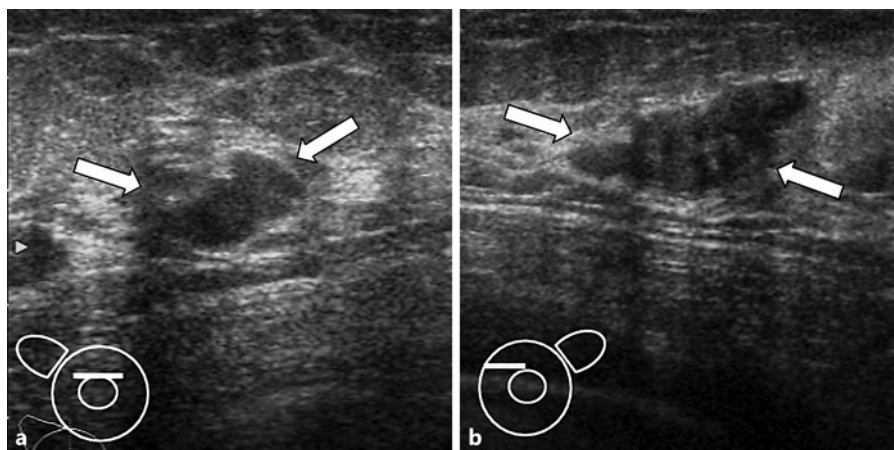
Ultrasonography findings. Breast ultrasonography revealed an irregular marginated hypoechoic mass measuring $15.1 \times 15.0 \times 9.4$ mm in the upper middle of the right breast (a) and an irregular marginated hypoechoic mass measuring $24.8 \times 21.9 \times 10.6$ mm in the upper inner quadrant of the left breast (b).
